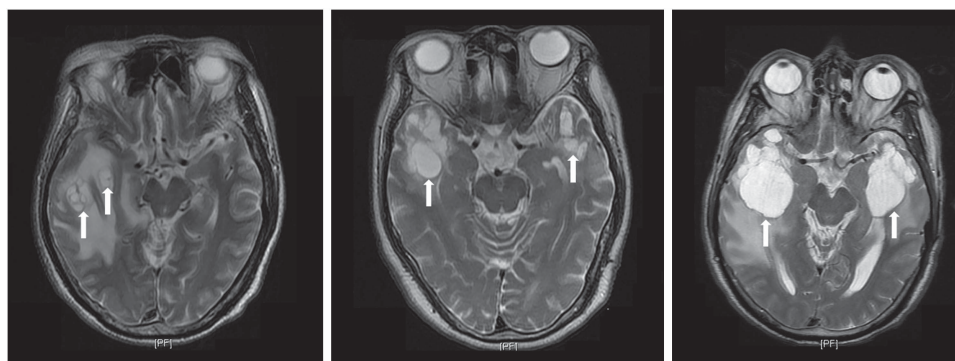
Representative axial T2-weighted magnetic resonance images in patients with multiple cysts in the temporal lobe.
